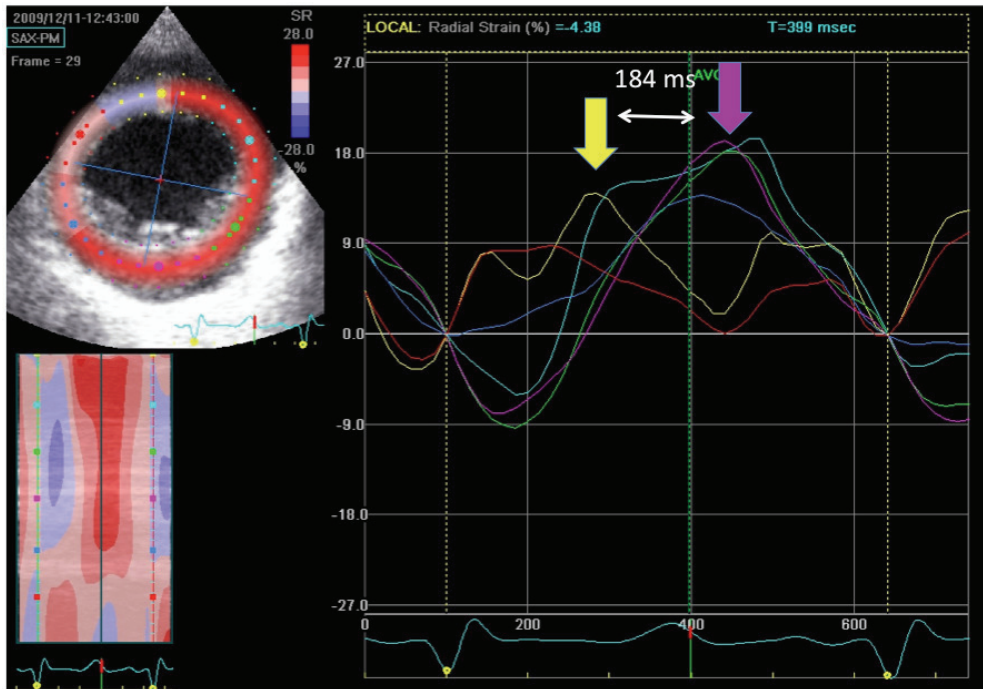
This image shows a parasternal short-axis view at the mid-ventricular level of a child with permanent right ventricular pacing for congenital complete AV block. The ventricular walls are divided into six myocardial segments (farb-coded). During one cardiac cycle, the time to systolic peak radial strain can be measured. The time delay between the septal and posterior wall (yellow and purple arrows, respectively), a parameter of LV dyssynchrony is estimated. There is significant LV dyssynchrony in this patient (184 ms, normally the time delay is < 130 ms). In addition, there is an inhomogeneous pattern of radial strain, with severely reduced peak radial strain values for all myocardial segments. (Radial peak strain values are presented as positive values).
